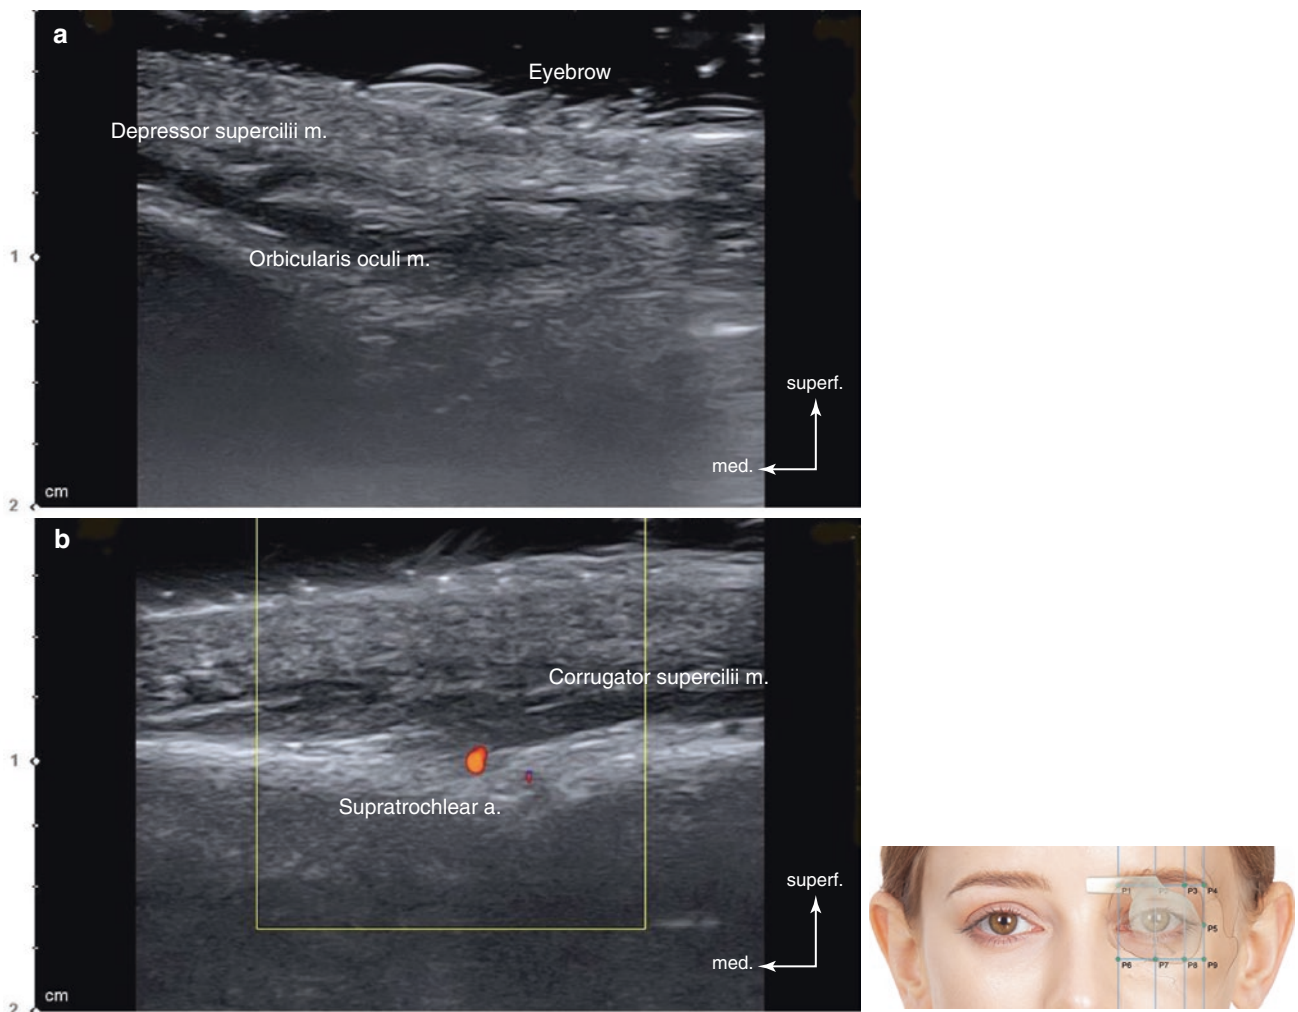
Ultrasonography of the intersection point of TL2 and PL1 (P1). (a) B mode (transverse view, 15 MHz by linear transducer), (b) Doppler mode (transverse view, 15 MHz by linear transducer), (c) B mode (sagittal view, 15 MHz by linear transducer), and (d) Doppler mode (sagittal view, 15 MHz by linear transducer). (Published with kind permission of © Hee-Jin Kim 2020. All Rights Reserved)
